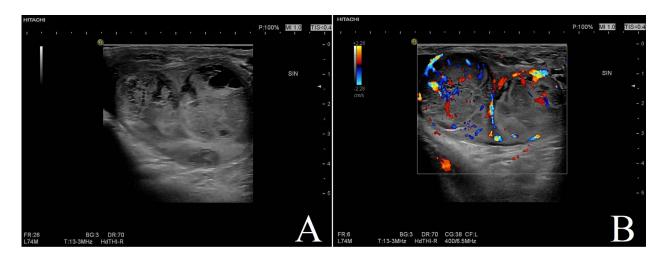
(A) Ultrasonic appearance of a left-sided tumor in the 77-year-old patient. (B) Color Doppler of the spermatocytic tumor.
